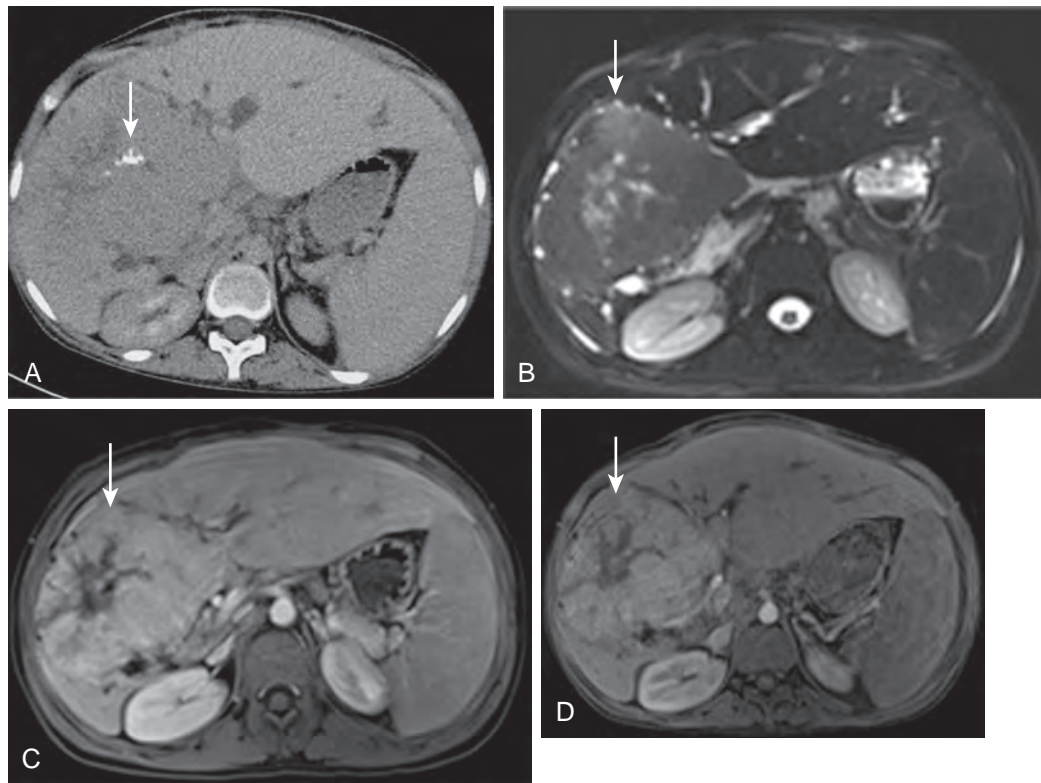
FLC: CT and MRI findings. A patient with a large fibrolamellar carcinoma (arrows). Note the central calcification as depicted on the nonenhanced CT image (A). The lesion is slightly hyperintense on the T2-weighted image (B), with areas of central necrosis. It shows strong enhancement on the arterial and portal venous images (C-D, respectively).
